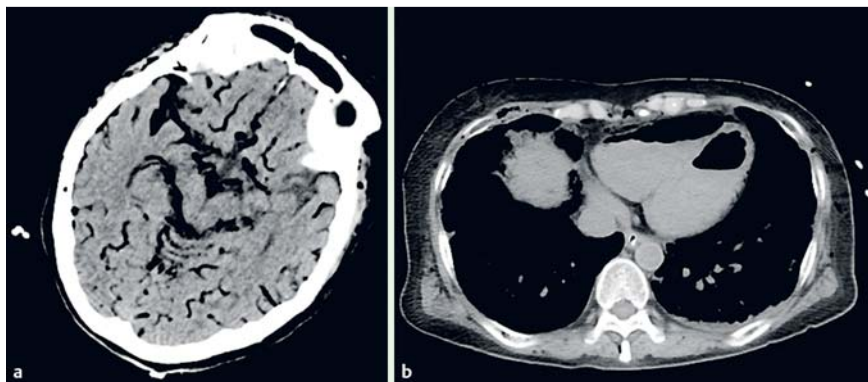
Computed tomography (CT) scan during resuscitation showing multiple gas emboli in the systemic arteries and veins of: a the brain; b the heart.
